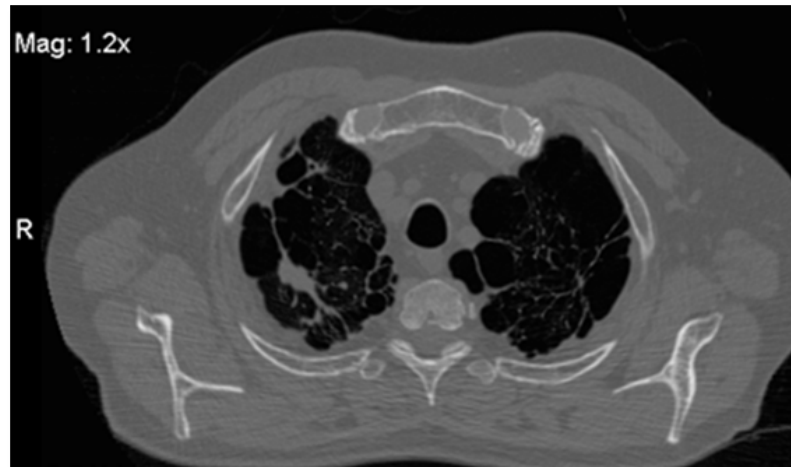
Chest CT of the pulmonary window, sequential images, fibrorectable, in lung apexes, contacting and thickening the homolateral pleurae.
